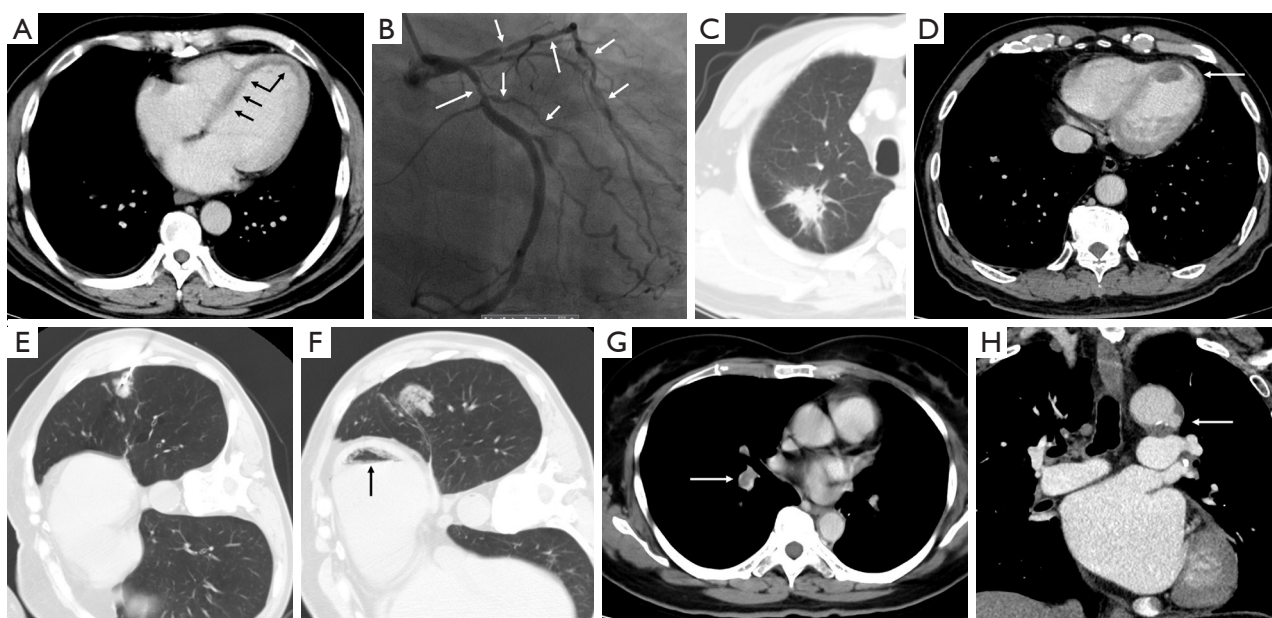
Blind spots on chest CT: heart and vascular structure. (A,B) A 45-year-old male with nasal NK/T-cell lymphoma and coronary heart disease. (A) The radiologist failed to identify subtle linear low-density shadows in the left ventricular wall (arrows), which are consistent with myocardial infarction. (B) Subsequent coronary angiography showed multiple stenoses (arrows) in the left anterior descending and circumflex coronary arteries. (C,D) A 70-year-old male with right lung cancer and a history of prior myocardial infarction. (D) Chest CT image revealing a low-density thrombus in the left ventricle, along with linear low-density shadows within the myocardium (arrow), indicating infarction. (E,F) A 72-year-old male with lung nodules in the left lower lobe underwent CT-guided biopsy. The immediate follow-up CT image after biopsy showed air within the left ventricle (black arrow), which is easily missed and lead to fatal result (F). (G) A 61-year-old female with metastases after left lung cancer surgery. The filling defects in the right middle and lower pulmonary artery (arrow), suggesting pulmonary artery embolism, was missed in the report. (H) A 66-year-old male with a missed low-density niche in the aortic arch on CT image (arrow), suggesting a penetrating ulcer. CT, computed tomography; NK, natural killer.
